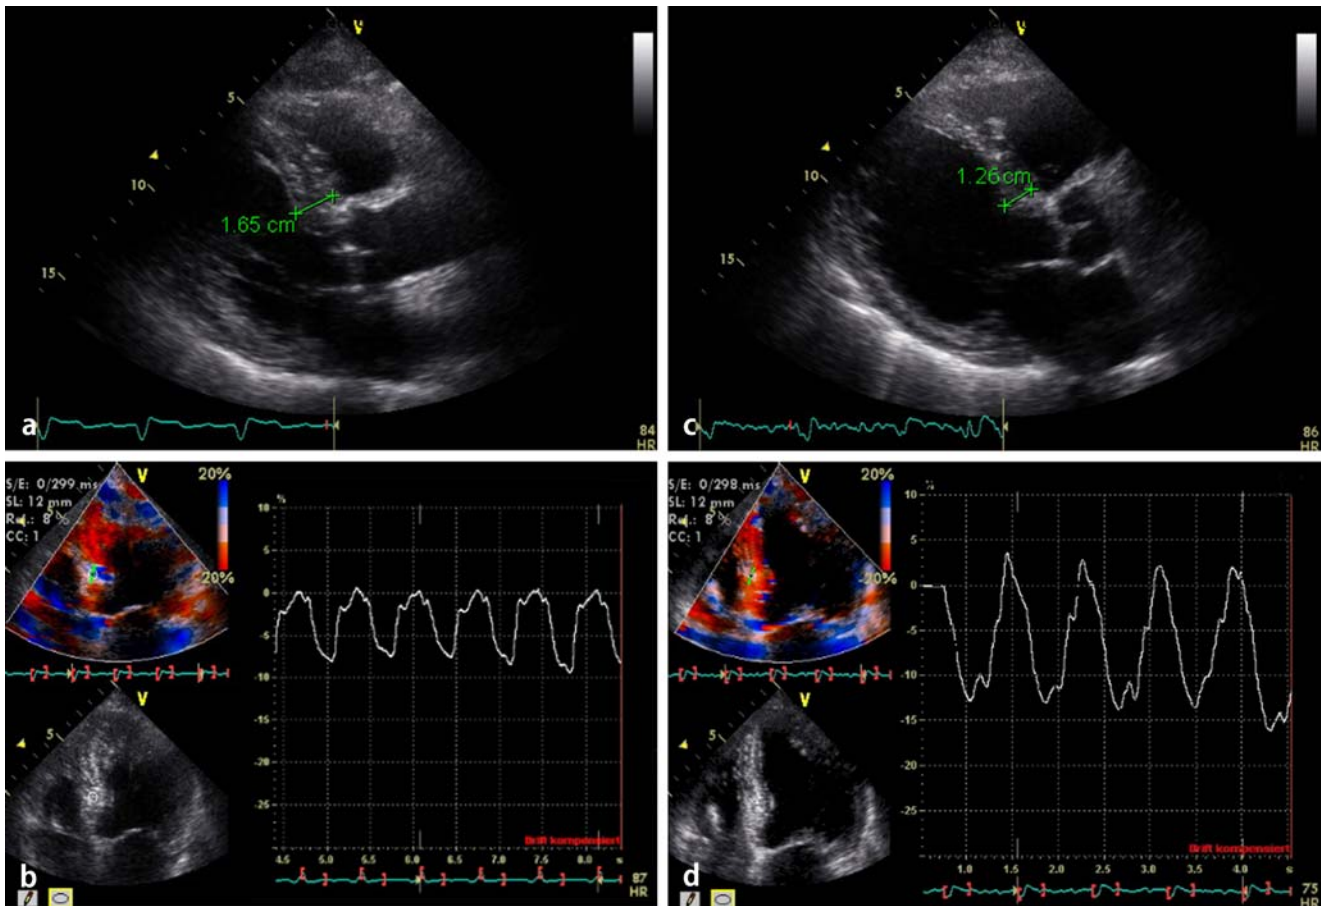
Parasternal long axis view with measurements of end-diastolic basal septum (panel a) and longitudinal strain as obtained from the apical four chamber view (panel b) before therapy. After therapy, an evident decrease in left ventricle septal thickness (panel c) and increase in longitudinal myocardial deformation (panel d) can be observed
